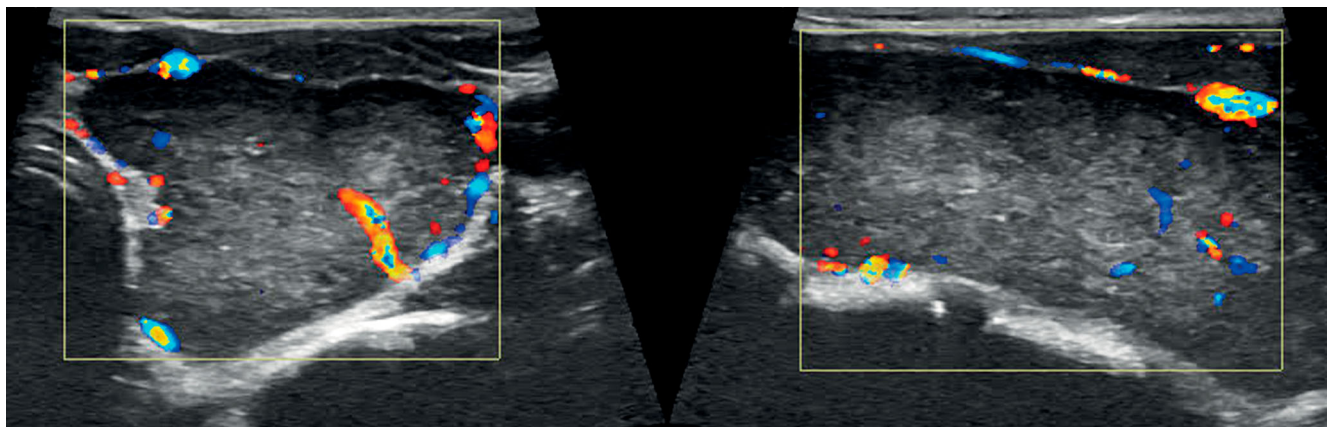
Solid hypoechoic thyroid nodule with increased peripheral and intranodal vascularity on ultrasound. ATA high suspicion sonographic pattern (ACR-TIRADS = 4 [5 points]).
